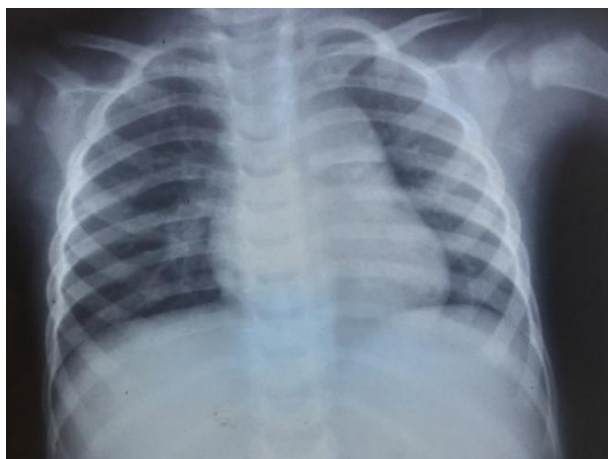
X-Ray chest on admission showing infiltration in right lower zone.
